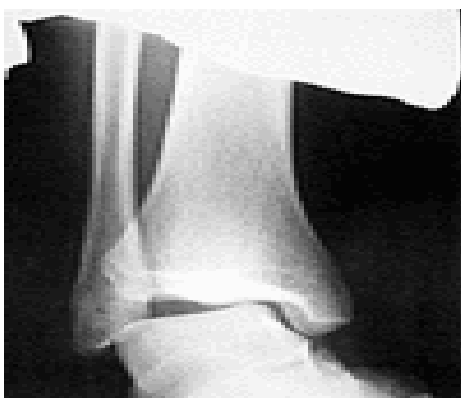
Talar-tilt stress radiograph. (Copyright2002 by the Hughston Sports
